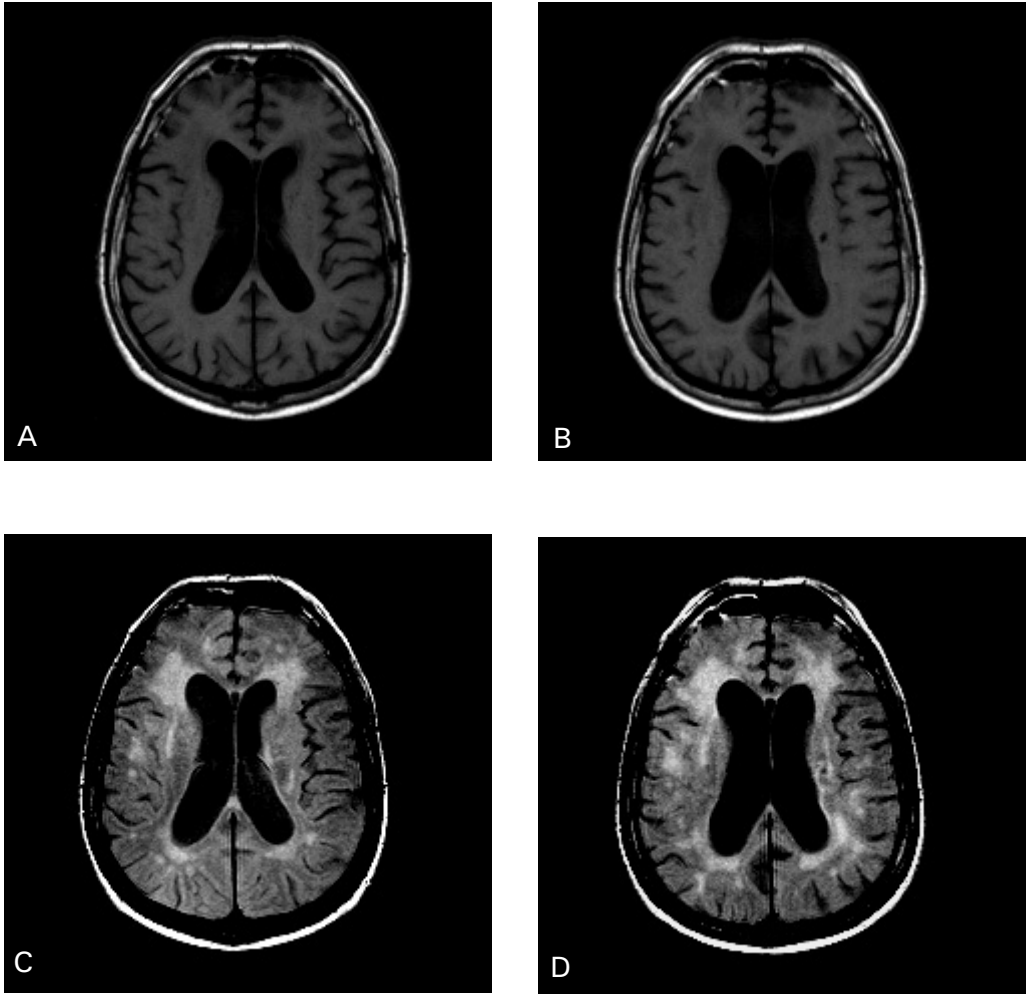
Incident lacunar infarct and progression of white matter lesions. A: T1-weighted spin echo MR image at baseline. B: T1-weighted spin echo MR image at follow-up with new hypointense lesion in the left periventricular white matter C: PD-weighted spin echo image at baseline. D: PD-weighted spin echo image at follow-up with more hyperintense lesions in both the periventricular as the subcortical region.
